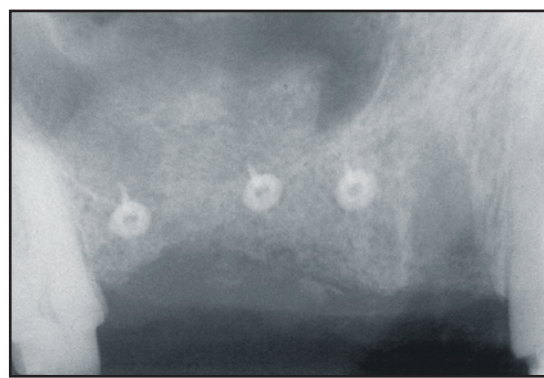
Immediate postoperative radiograph of site #3 through #5 showing localized sinus floor elevation at site #3 and #4 and the residual extraction defect at site #5.
